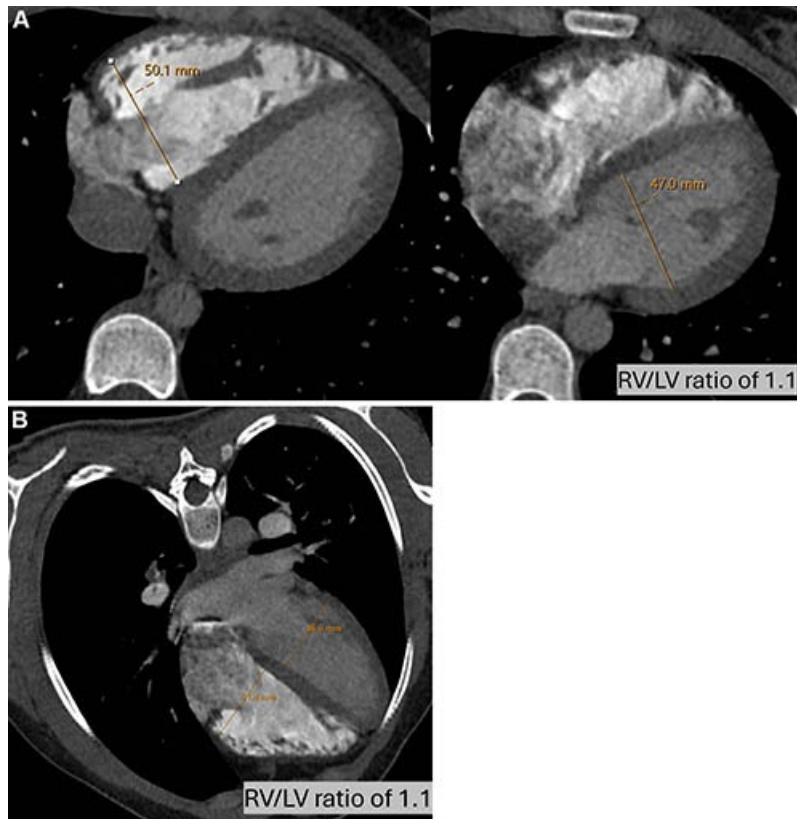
Assessment of right heart enlargement on pulmonary CT angiography/MR angiography examinations. (A) Measurement of right ventricle (RV) and left ventricle (LV) diameters and calculation of the RV/LV ratio on axial CT angiography image reconstruction. RV/LV ratio is >1.0 , above the threshold for classification of RV enlargement in the Pulmonary Embolism Reporting and Data System (PE-RADS). (B) Measurement of RV and LV diameters and calculation of the RV/LV ratio on four-chamber CT angiography image reconstruction. The RV/LV ratio is >1.0 , above the threshold for classification of RV enlargement in PE-RADS.
